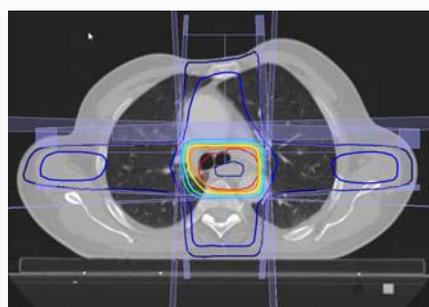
CT-scan on the same level as Figure 1. This is a CT scan for radiation planning with target area (red) and isodose lines (orange-yellow-green-light-blue).
